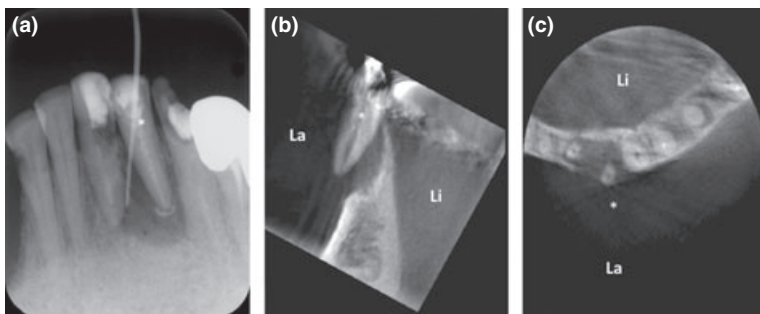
Type V-3: The whole root of the mandibular left lateral incisor (*) was extruded from the labial bone plate. (a) Periapical radiograph. (b) Labio-palatal slice image of the CBCT (3DX). (c) Horizontal slice image of the CBCT (3DX). La: labial side. Li: lingual side.
